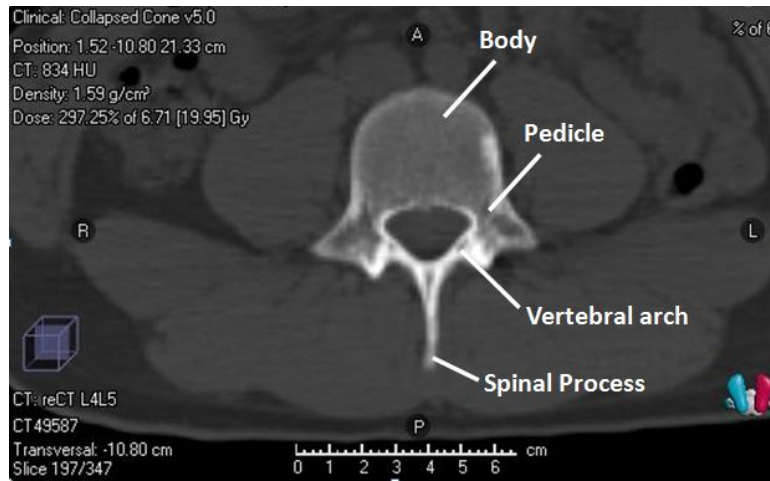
Vertebrae structures measured from the lumbar vertebrae section of CT images from spine SABR patients.
